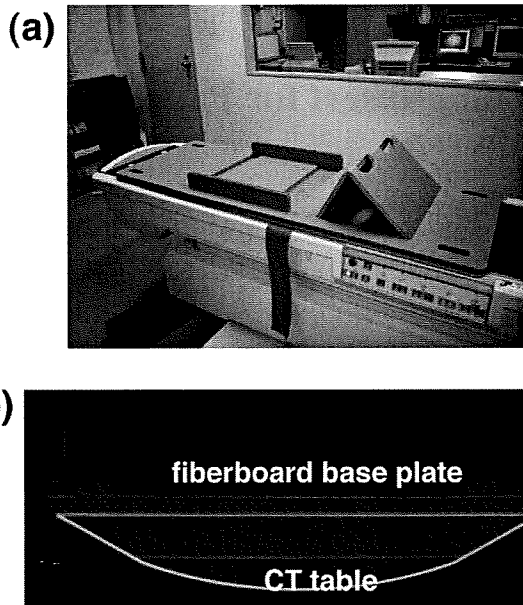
A home-made fiberboard base plate characteristics: a view (a) and a CT image (b).
